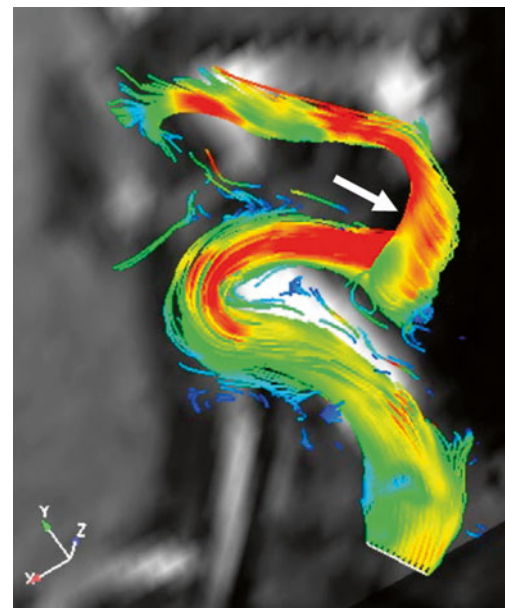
3D streamline visualization of blood flow within carotid siphon obtained from 4D PC MRI of a healthy volunteer depicting helical flow pattern at supraclinoid ICA segment (arrow)
